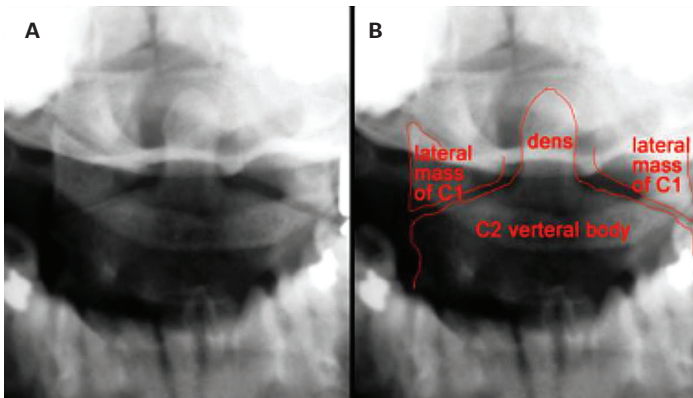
Open-mouth odontoid view x-ray showing dens, C2 vertebral body, and lateral masses of C1. (A) Unlabeled; (B) Labeled.
